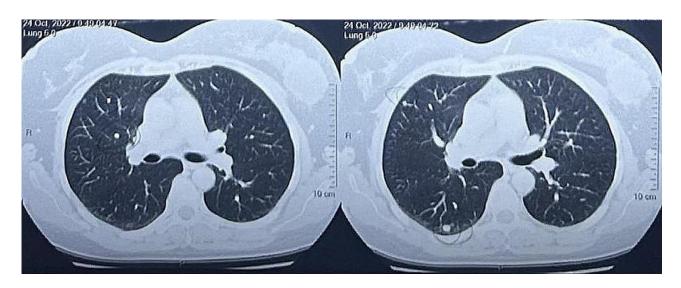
CT scan showing a left breast mass and pulmonary nodules.
